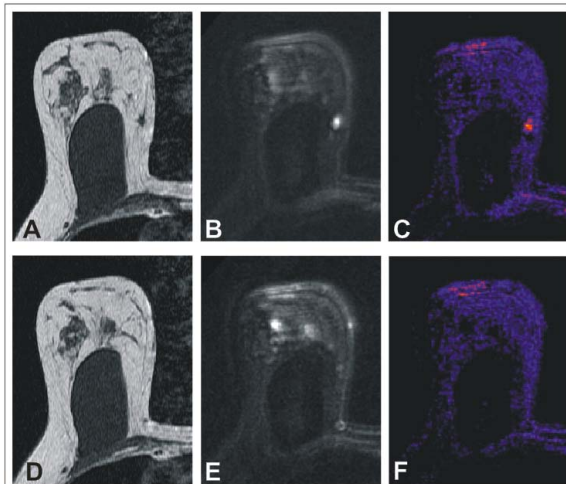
A+D Axial, pre-contrast T1W images; B+E DW-images; C+F corresponding ftADC maps. Note that only one of the DWI-bright lesions in (B+E) is visible on the ftADC map in (C). At subsequent lumpectomy the lesion in (B) was confirmed to be an invasive ductal carcinoma.
